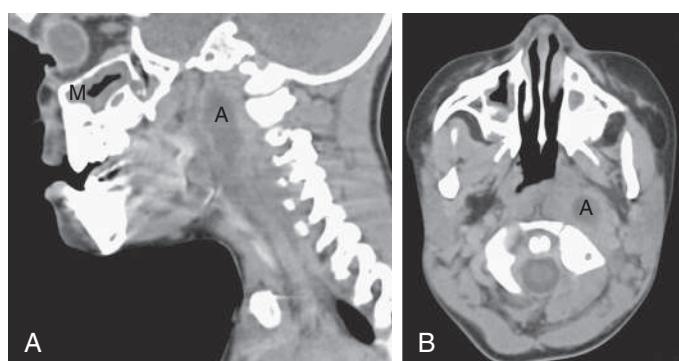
CT of parapharyngeal abscess in a 3-yr-old child. A, Sagittal section demonstrating parapharyngeal abscess (A) and mucosal swelling (M) in the maxillary sinus. B, Coronal section of parapharyngeal abscess (A).
